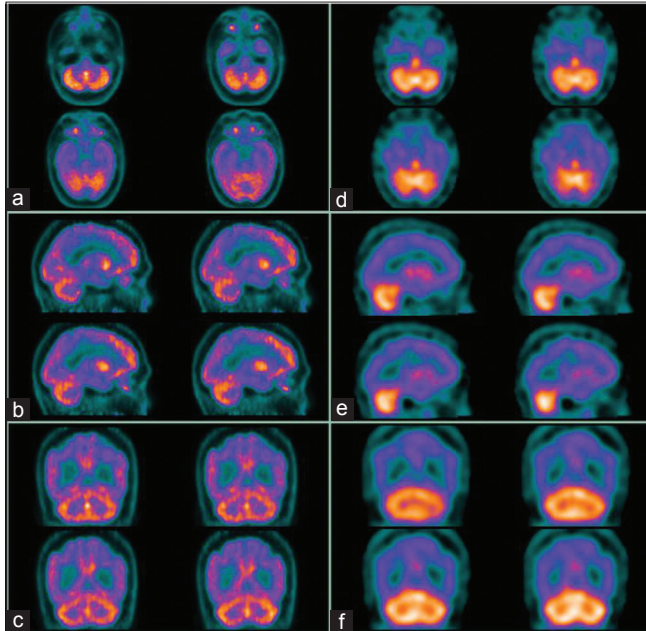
Two sets of three tomographic slices of positron emission tomography and single-photon emission computed tomography. On the left half, we see transaxial, sagittal, and coronal slices of brain ^{18}F -fluorodeoxyglucose-positron emission tomography (a-c, respectively). On the right half, correlative transaxial, sagittal, and coronal slices of cerebral perfusion single-photon emission computed tomography (d-f, respectively) are displayed. We note the difference between the cerebellum and cerebral cortex in the two different techniques with a marked relative hyperperfusion and only slightly relative hypermetabolism in the cerebellum when compared with other brain areas
